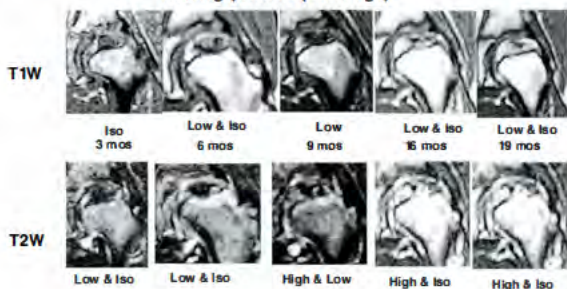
Time-sequential changes of LCPD on MRI
